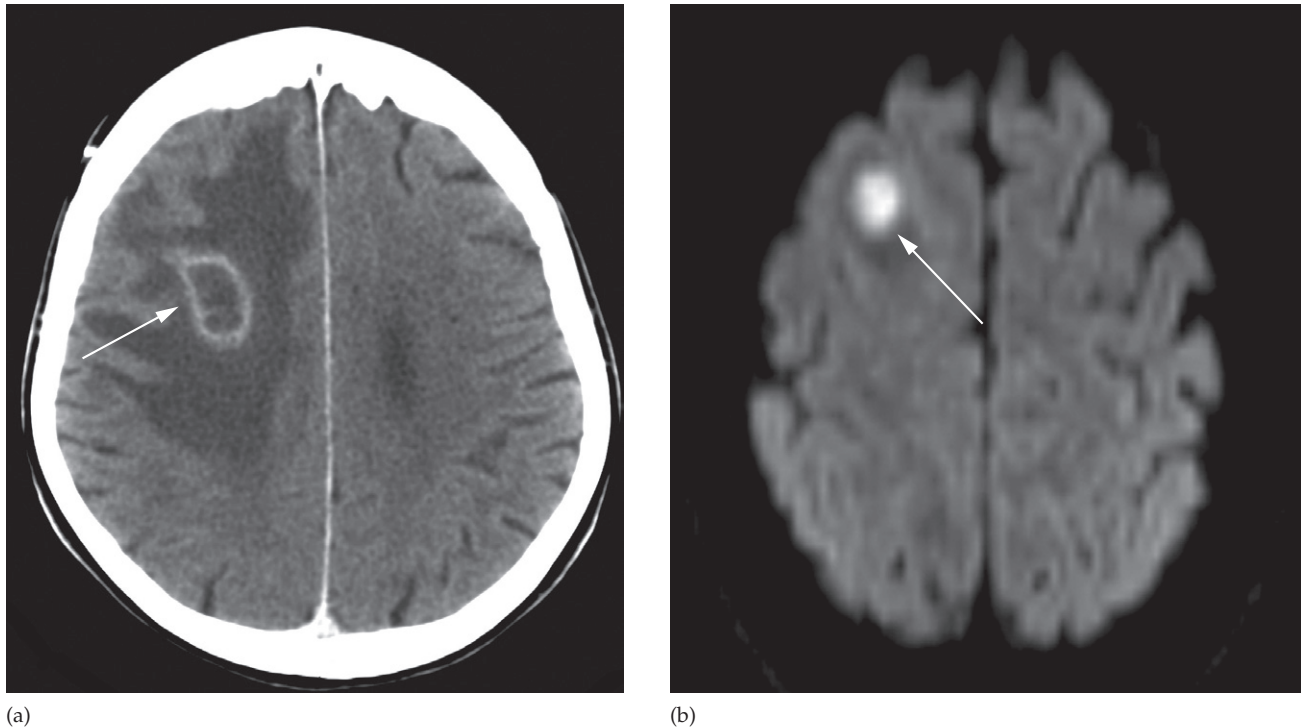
Cerebral abscess. (a) Post contrast CT scan showing a right frontal ring-enhancing lesion with surrounding vasogenic oedema (arrow). (b) DWI showing the contents of an abscess (arrow) with restricted diffusion in keeping with pus.
